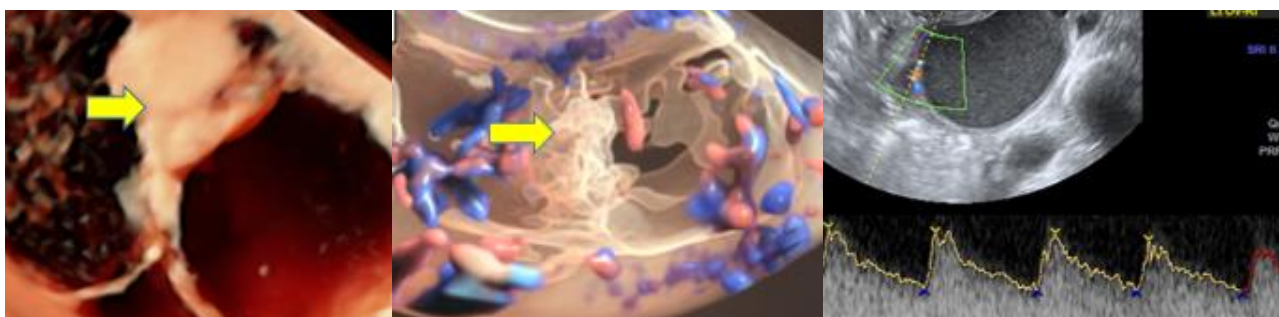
2D/3D ultrasound image of endometrioma: Hiperefogenic bulk on the wall of the cyst(a), no vascularization on angio mode(b). Multilocular appearance of the cyst. The ground glass echogenicity and hyperechoic bulk , Vascularization on the wall of the cyst – Ri.0.54(c)
